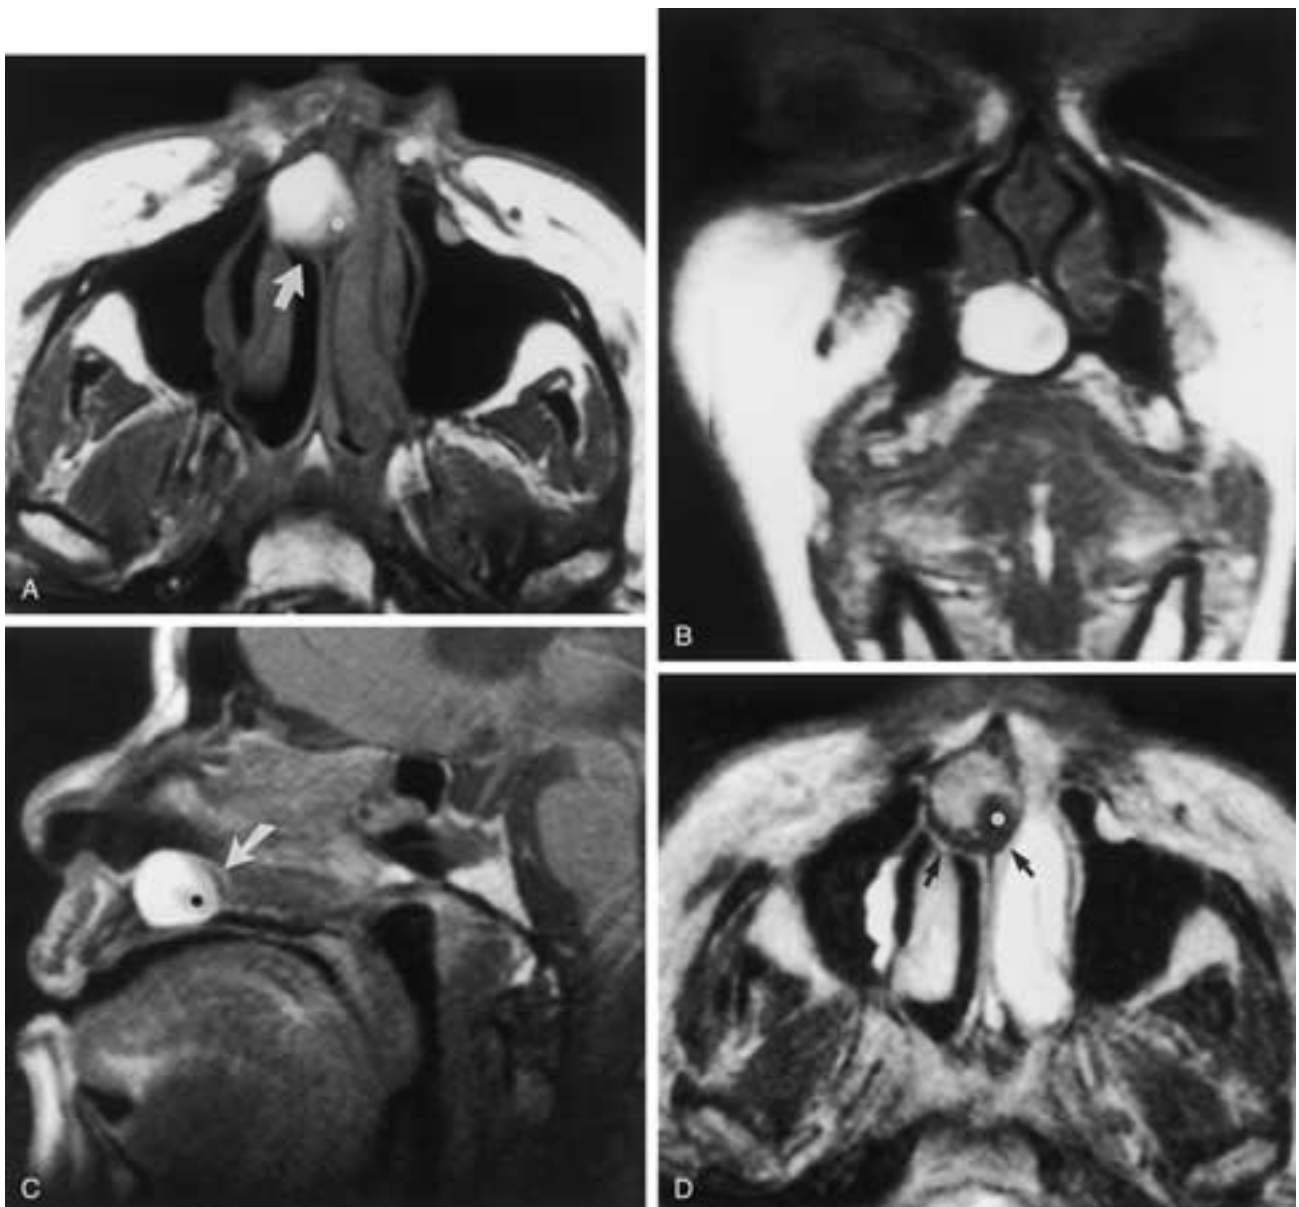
Incisive canal cyst. Axial T1-weighted MR images in the (A) axial, (B) coronal, and (C) sagittal planes demonstrate a unilocular lesion of high signal intensity in the midline of the hard palate. There is a small area of low signal intensity in the posterior aspect of this lesion (*dots*). Bony expansion can be appreciated (*arrows*). D, Axial T2-weighted MR image reveals relatively intermediate signal in the lesion. The solid component (*dot*) and bony expansion (*arrows*) are better defined.
